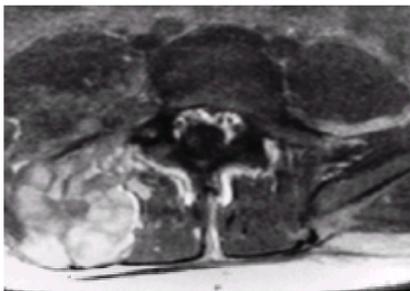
Neurofibromatosis in a 16-year-old patient. The magnetic resonance image at the level of L4–5 demonstrates a large plexiform neurofibroma that invades the neural axis. It extends from the level of L3 to the sacrum.
